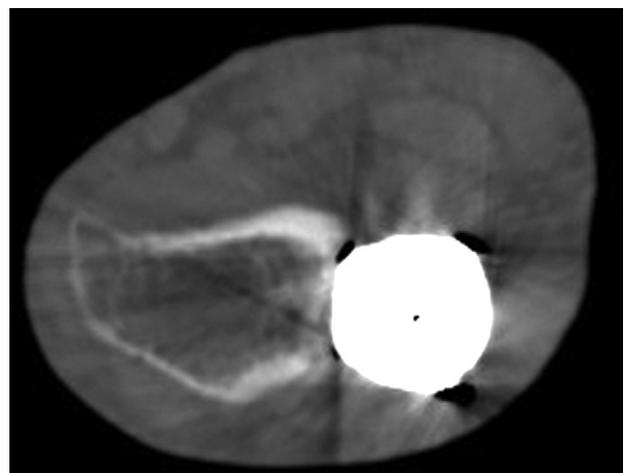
Computed tomographic image: axial view of implant at the distal part of radius, patient 9.
